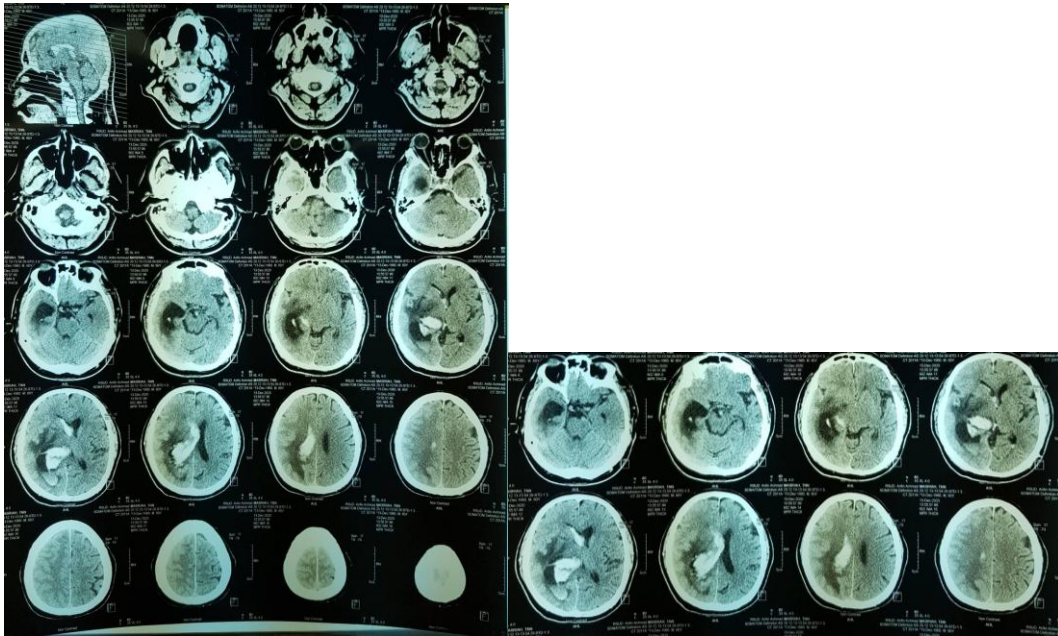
Head CT scan of the patient obtained on admission to the intensive care unit.
